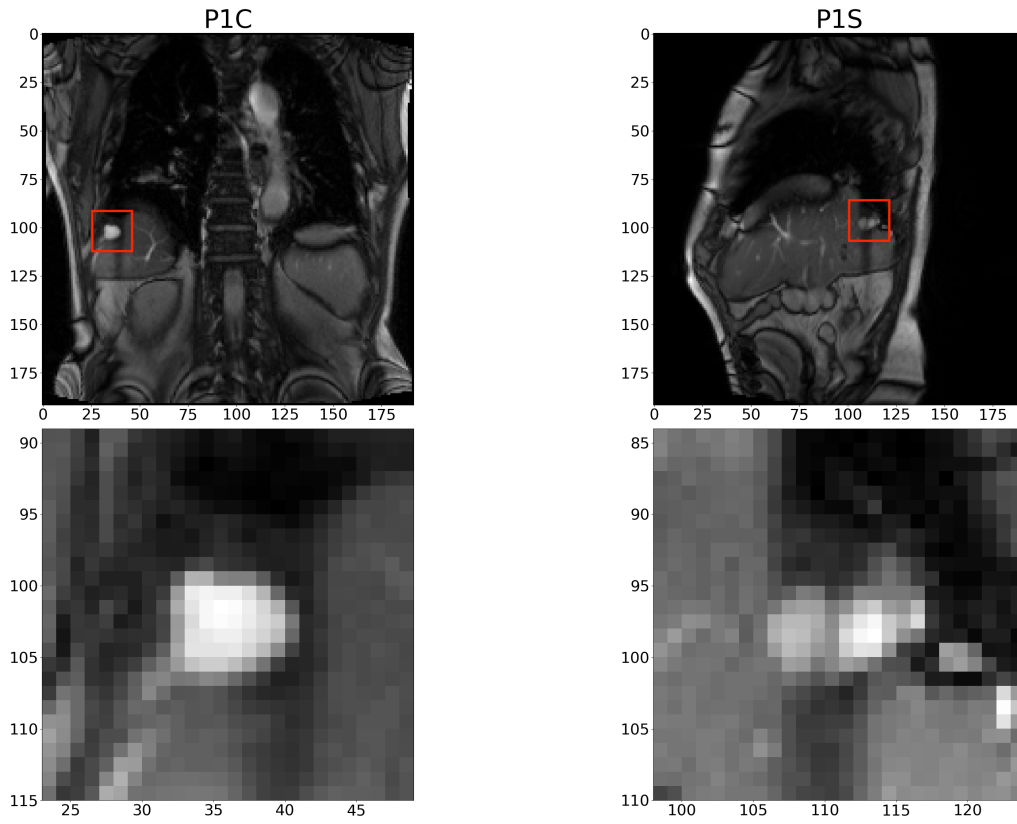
MRI images of P1 and MRI images zoomed on the tumor.
